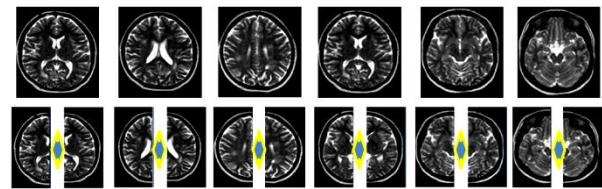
Separation of the right and left hemispheres of all slices of an MR image
